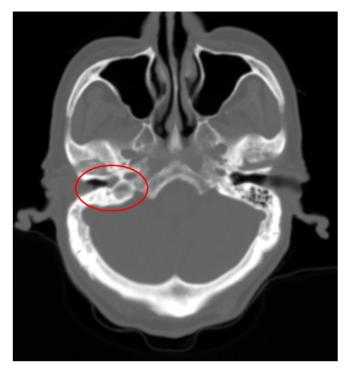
Paranasal sinus computed tomography shows middle ear effusion (circle).
